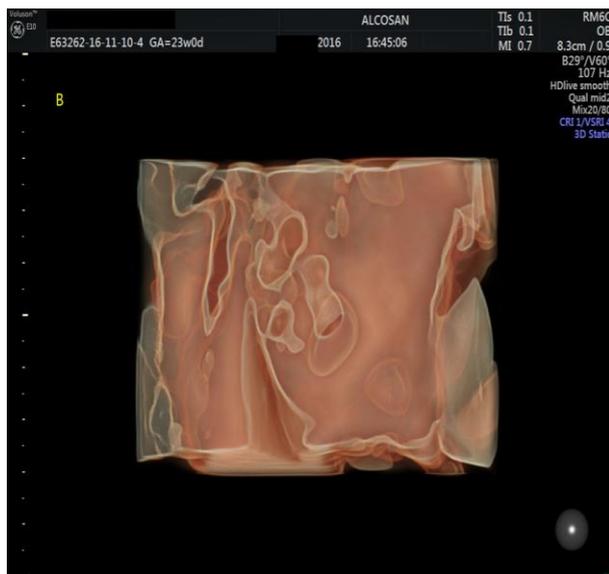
Fetus B: Unilateral multicystic dysplastic kidney (3D Static ultrasound examination)
